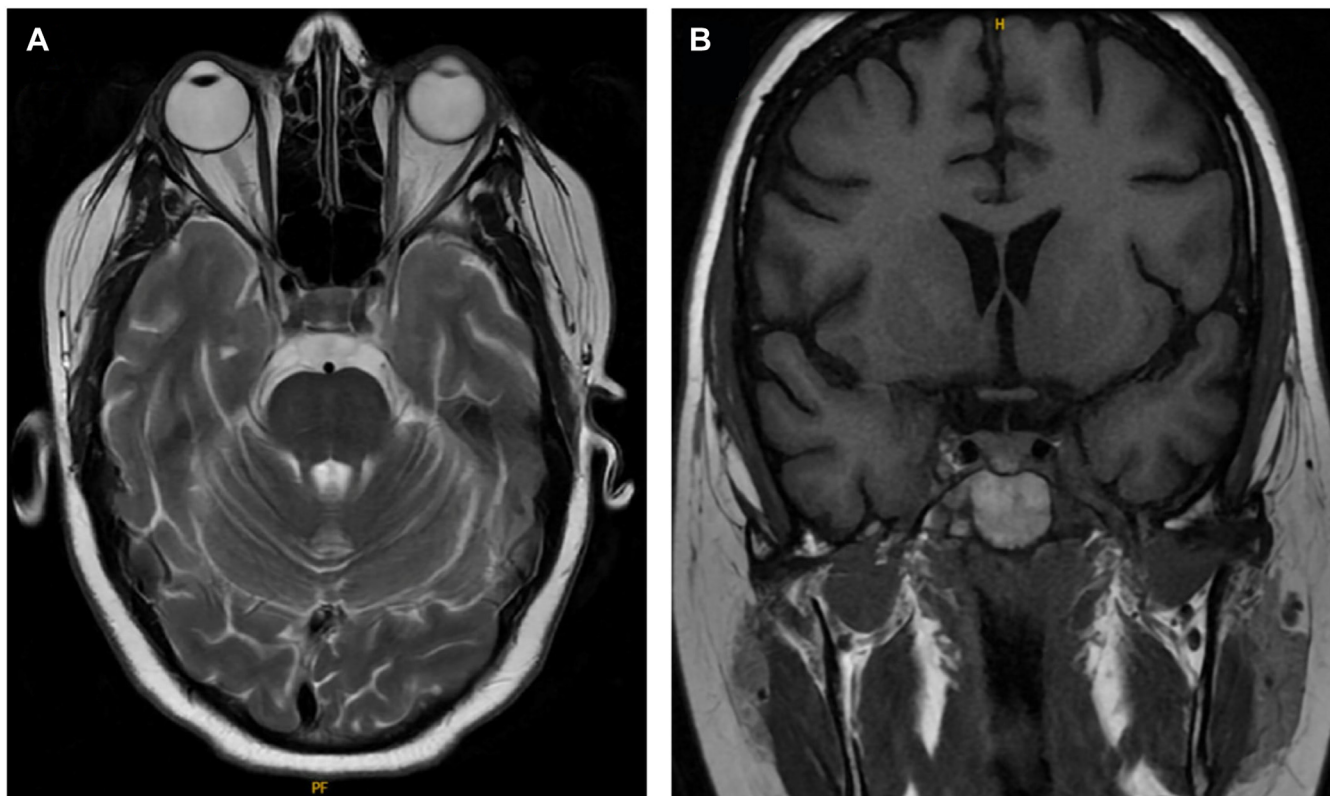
Pituitary magnetic resonance imaging showing pituitary heterogeneous hypoenhancement but no mass in axial view (A) and no suprasellar mass in coronal view (B).
